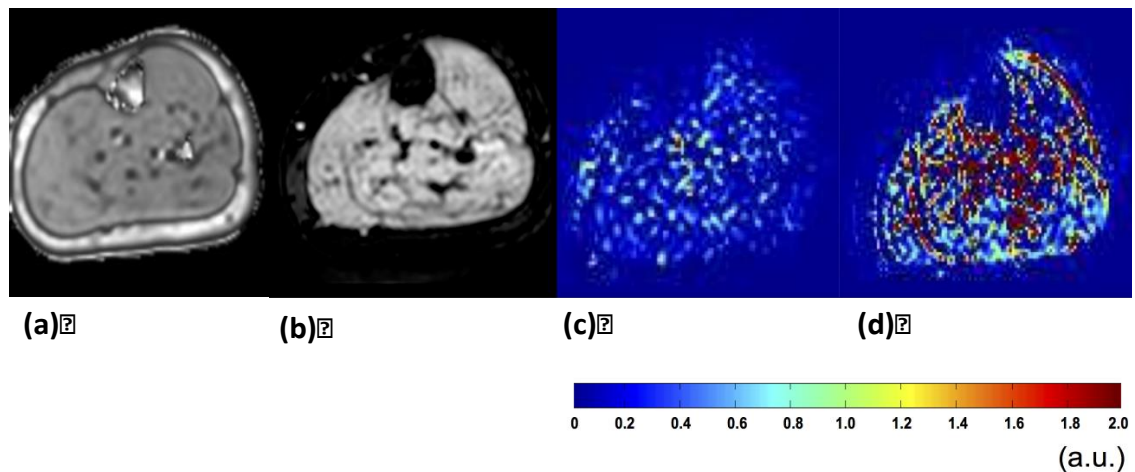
Comparison of GRE BOLD-MRI and pCASL. A higher spatial resolution is achieved with GRE (a) compared with pCASL (b). Perfusion maps demonstrate change in perfusion as measured with pCASL during ischaemia (c) and reactive hyperaemia (d) (signal intensity for perfusion maps in arbitrary units)
